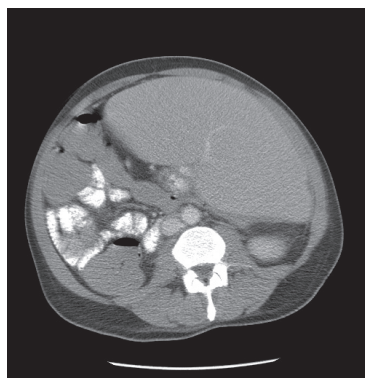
Computed tomography scan of extensive splenomegaly (135 x 135mm [96 x 96 DPI]).
